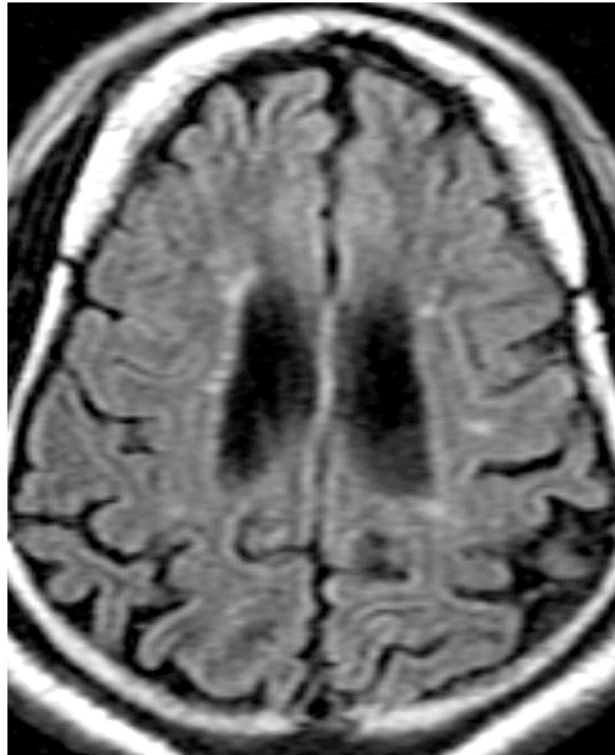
Brain magnetic resonance imaging of patient 2. Axial fluid attenuation inversion recovery (FLAIR) image demonstrates numerous punctate foci of high signal intensity in the periventricular white matter.
